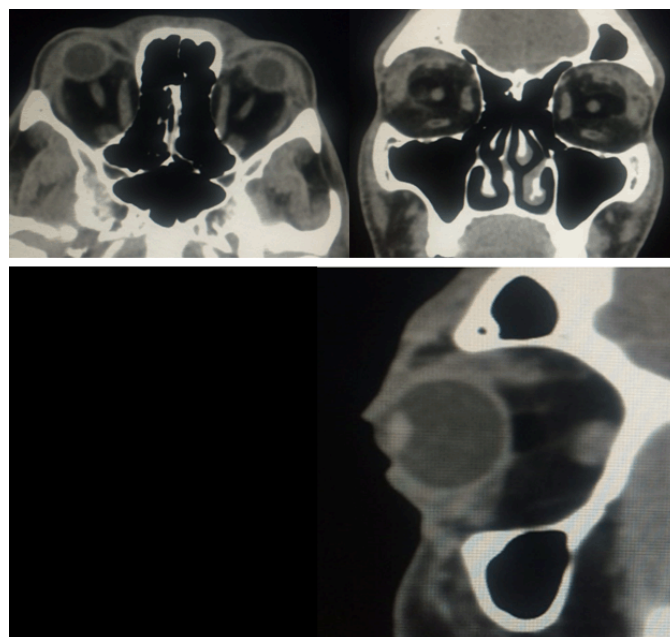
Contrast-enhanced CT in axial, coronal and sagittal plane shows a grade III bilateral exophthalmia with enlarged extraocular muscles and extra conal fat infiltration.
